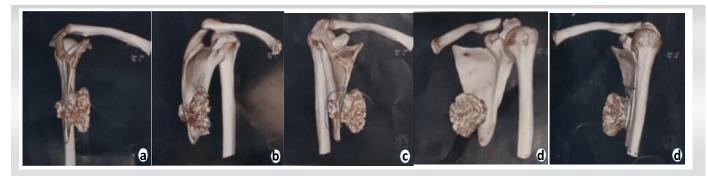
3D Computed tomography scan showing ventral osteochondroma.
